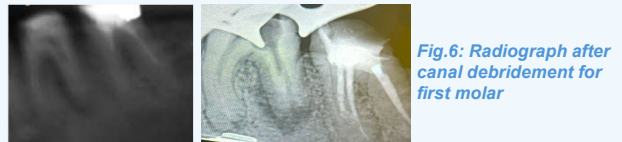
Radiograph after canal debridement for first molar
